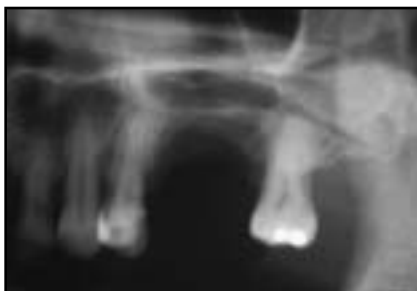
(left) Orthopantomogram (patient NL) shows atrophic edentulous ridge at maxillary left second premolar and first molar sites.
